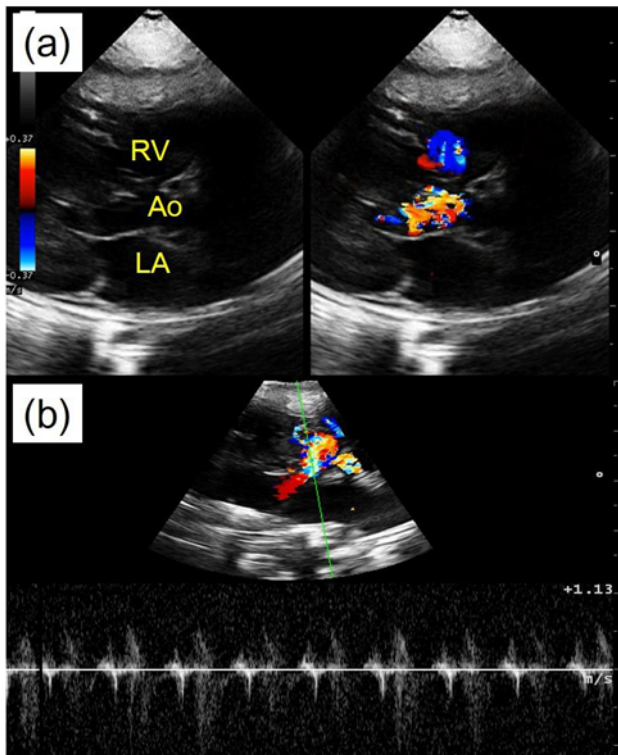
On day 28, the (a) B-mode and (b) Doppler studies showing (a) right-to-left shunt from right ventricle (RV) to left ventricle across the ventricular septum defect, indicating development of Eisenmenger syndrome. Ao: Aorta.
